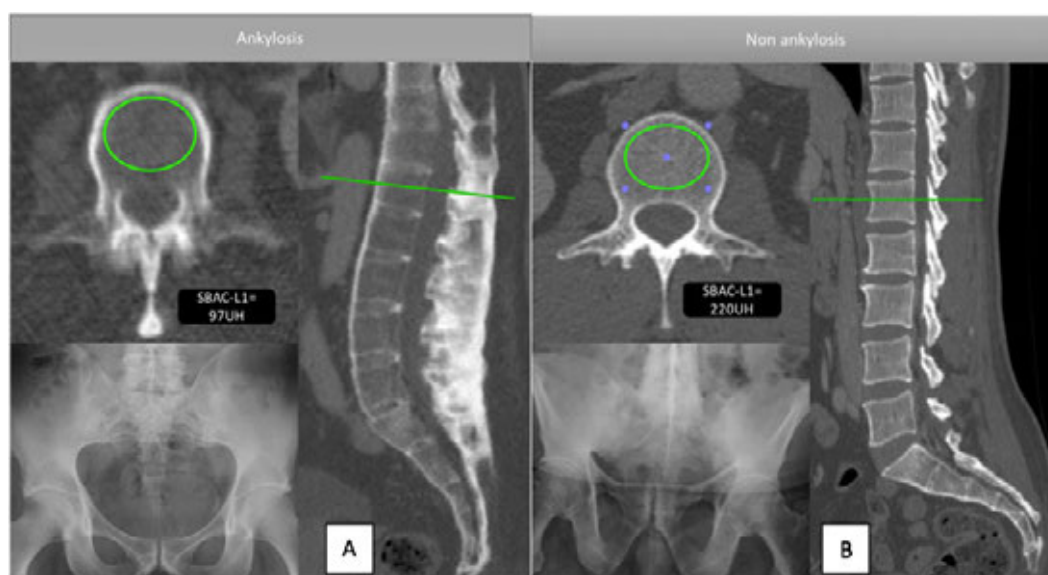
AS patients with sacroiliac joint ankylosis on radiography (A and B). Ankylosed spine in its anterior and posterior parts (A) and normal pattern (B) on sagittal slices. The SABC-L1 was calculated on axial slice of the first lumbar vertebra at 97UH in ankylosed versus 220UH in the non ankylosed spine.
